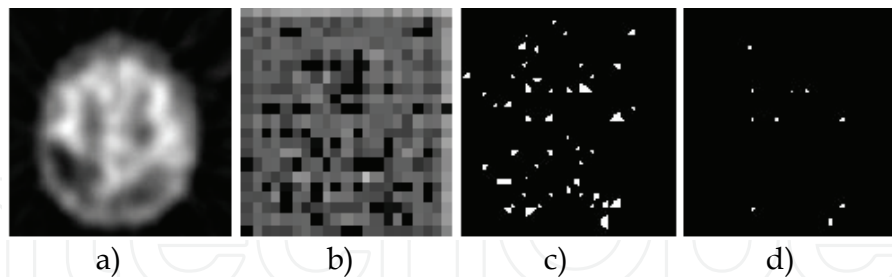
Disparities detection in cerebral SPECT image: a) original image, b) its morphological X component, c) disparities on low dissimilarity level, d) disparities on high dissimilarity level.
